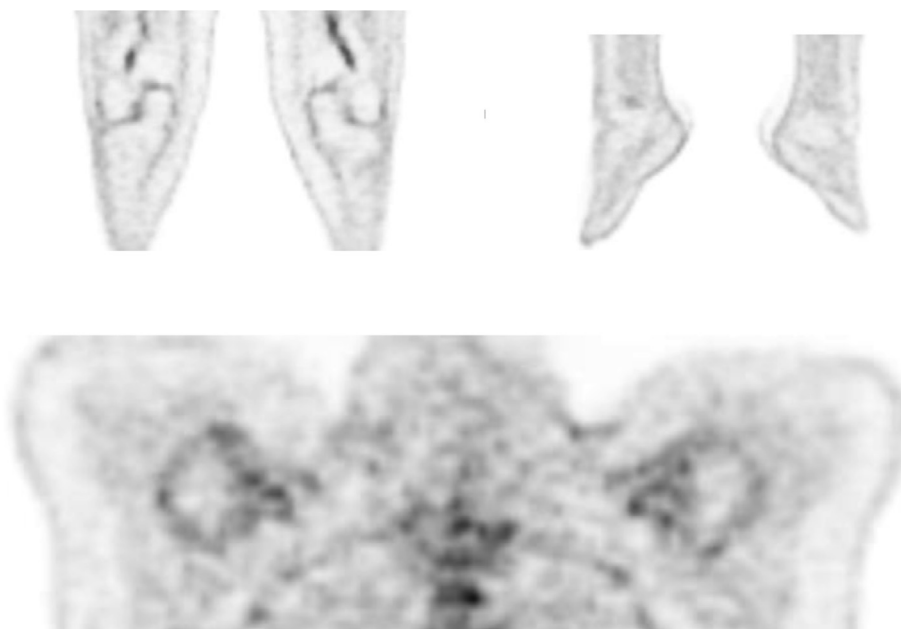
PET coronal section of the knees, ankles [upper row] and shoulders [lower row] showing the mild increased FDG uptake (SUV max around 3.0) around the knees and shoulders (arrows) and physiological uptake around the ankles.
